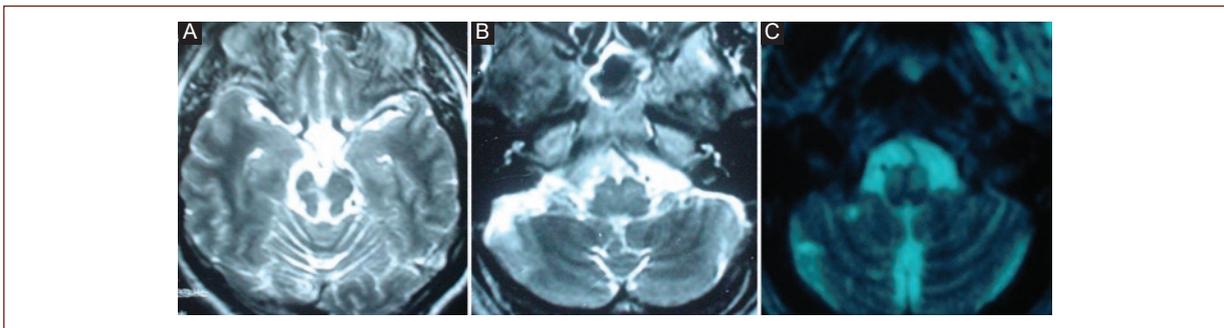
(Patient 18) Magnetic resonance imaging. Axial T2-weighted imaging A-C: showing multiple, chronic infarctions in the vertebrobasilar territory (cerebellum and mesencephalon), and olivary hypertrophy.
